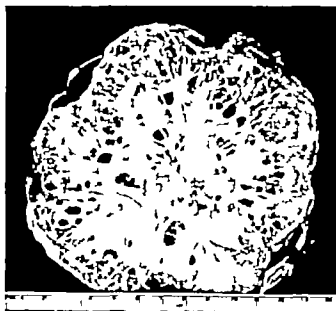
Gross photograph of a cystadenoma of the pancreas. Note radiating fibrous bands. (From Hauko R. S. Am. J Roentgenol 63 234-245 1950)
